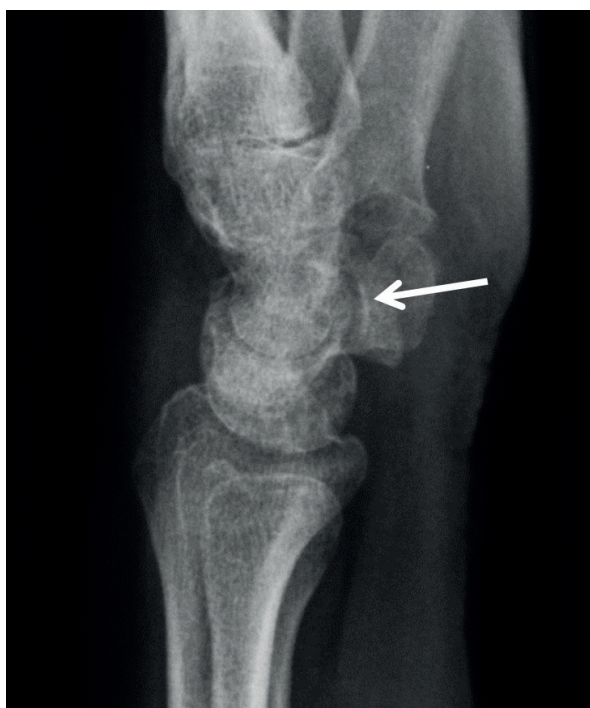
Lateral radiograph of the wrist showing pisotriquetral osteoarthritis (arrow).
